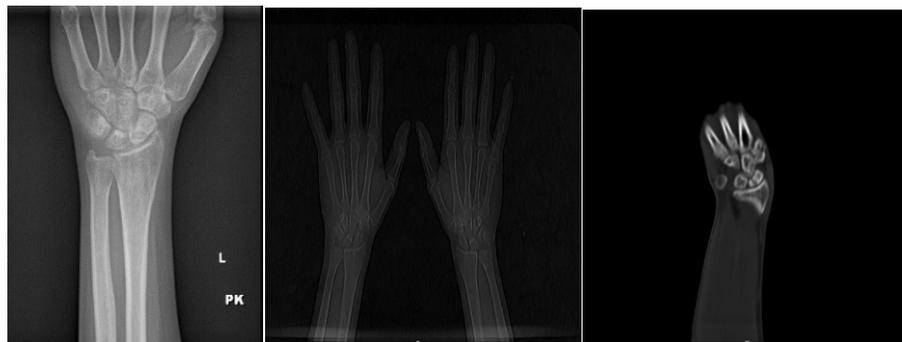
X-ray showing fracture of the scaphoid involving the waist with sclerosis of the proximal pole which is complimented by CT image
